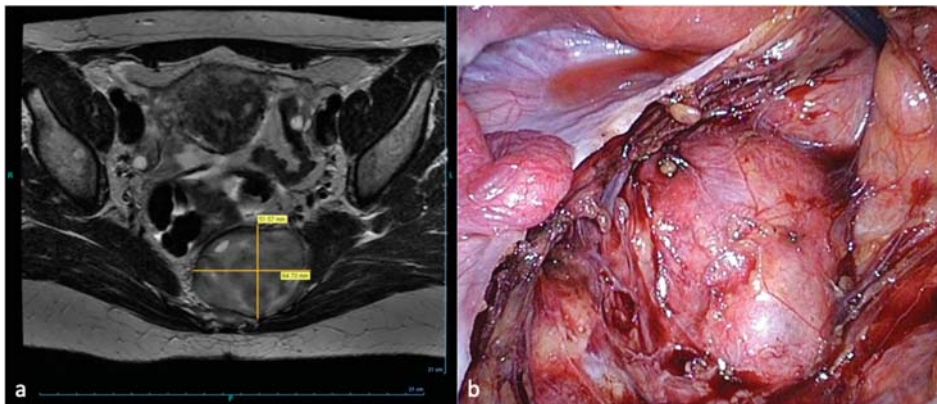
Laparoscopic resection of a sacral plexus schwannoma left. (a) MRI-presacral schwannoma (b) Corresponding intraoperative findings.
